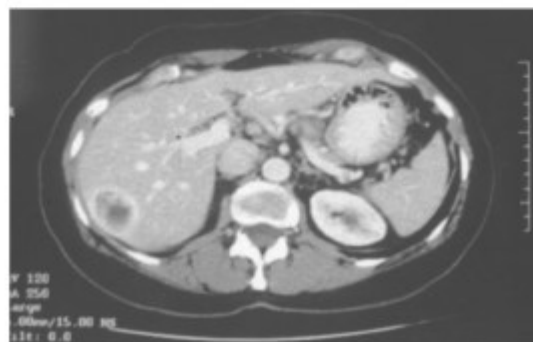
CT scan image of a 3.5-cm metastasis in the right lobe of the liver.
